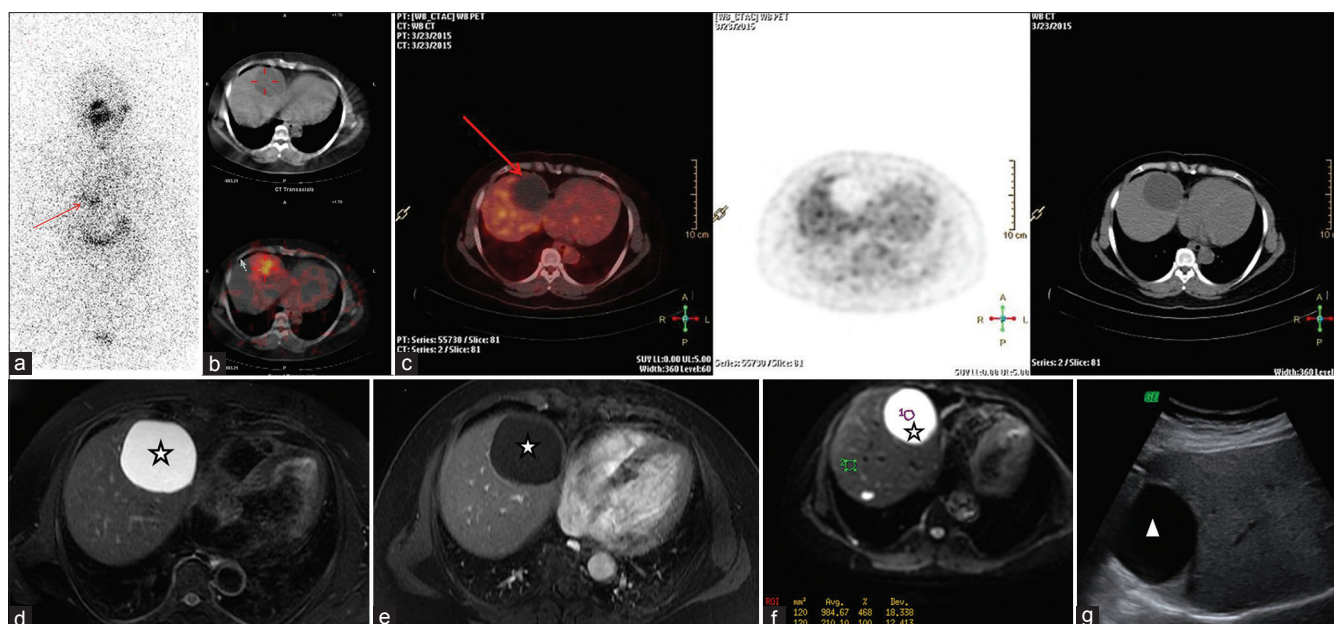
The diagnostic ^{131}I scan (a) showing iodine-avid focus in segment VIII of liver; Correlative SPECT CT [Figure 2a] and PET CT images (c) in abdomen window shows a well-defined round hypodense lesion in segment VIII of the liver, which showed iodine avidity on SPECT scan. T2W image (d) showing well-defined hyperintense lesion (star) in segment VIII with no significant enhancement in postcontrast fast spoiled gradient recalled (FSPGR)-echo images (e). Diffusion MRI (f) showed facilitated diffusion with high apparent diffusion coefficient (ADC) values. The correlated USG (g) shows anechoic lesion with posterior acoustic enhancement (arrowhead). All these imaging features were suggestive of simple cyst of the liver
